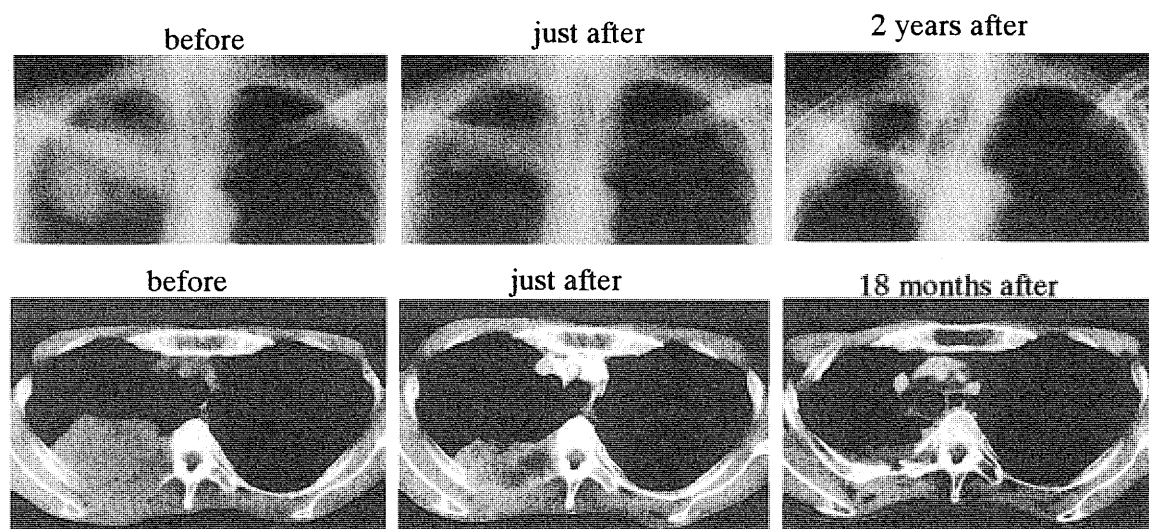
A change in chest X-ray findings and CT images in a 66-year-old male with squamous cell carcinoma of the lung treated with hyperthermia combined with radiation therapy. After the combined treatment, the tumour shrank and showed low density area, which is speculated as the effect of hyperthermia.
